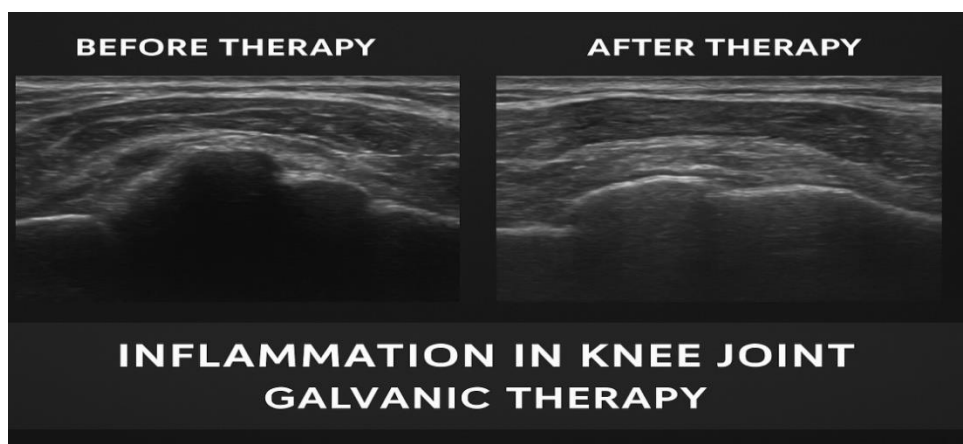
Ultrasound images demonstrate the reduction of inflammation in a knee joint after galvanic therapy
